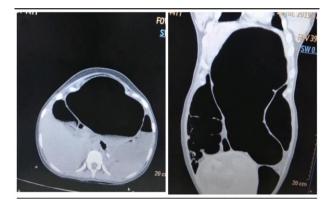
CT scan of abdomen.
